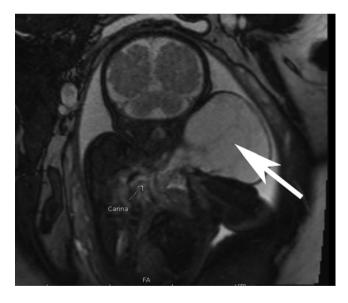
The coronal section of a fetal MRI demonstrate the appearance of a large cervical lymphatic vascular malformation, an *arrow* is pointing at the malformation, it is extending from the fetal left neck and causes minimal compression of the midline airway. The mass extends into the upper left chest but does not cause significant airway compromise. This vascular malformation was not particularly vascular and would not be expected to critically compromise the airway at delivery. However, rapid enlargement post-delivery is not uncommon. Conventional delivery followed by intubation would be the safest way to prevent development of airway compromise until the vascular malformation can be fully evaluated postnatally
